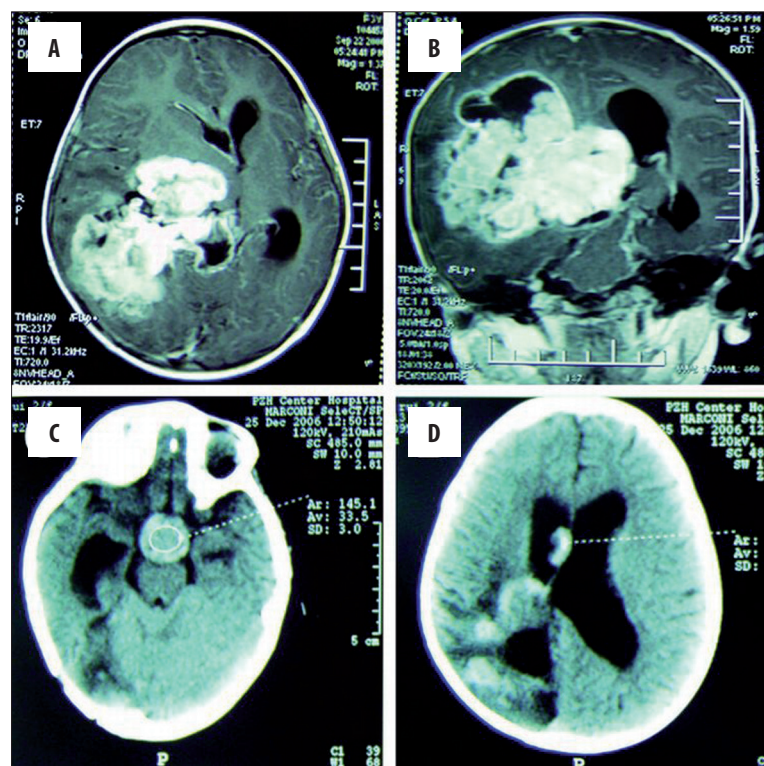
Radiologic images. (A) Enhanced MRI: a huge tumor with homogeneous enhancement by Gd-DTPA in the right lateral ventricle, necrosis in the center of lesion (Axial); (B) Enhanced MRI (Coronal); (C) Enhanced CT (4 months postoperation): a metastasis in suprasellar cistern (via CSF pathways); (D) Enhanced CT (4 months postoperation): a recurred tumor located at right lateral ventricle.
